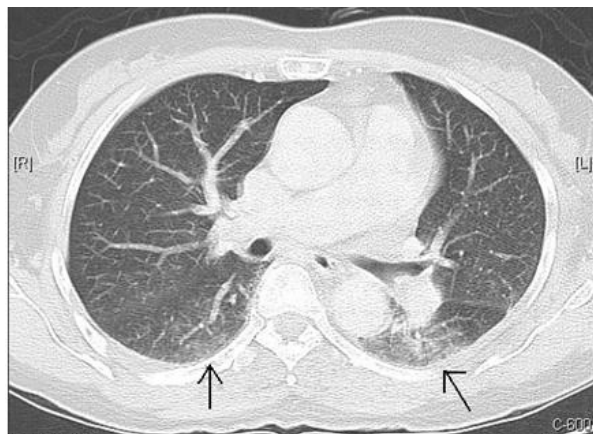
Chest computed tomography revealed ground-glass opacities in the dependent areas of both lower lobes of the lungs (arrows). No other pathological abnormalities were identified.
